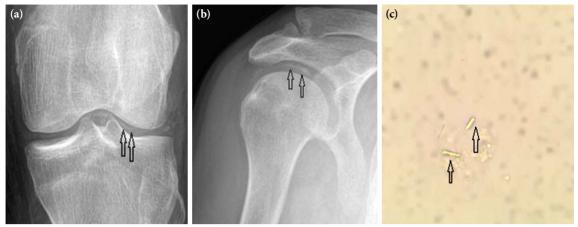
Chondrocalcinosis appearance in the (a) left knee and (b) right shoulder on a direct radiograph, and (c) calcium pyrophosphate deposition.
